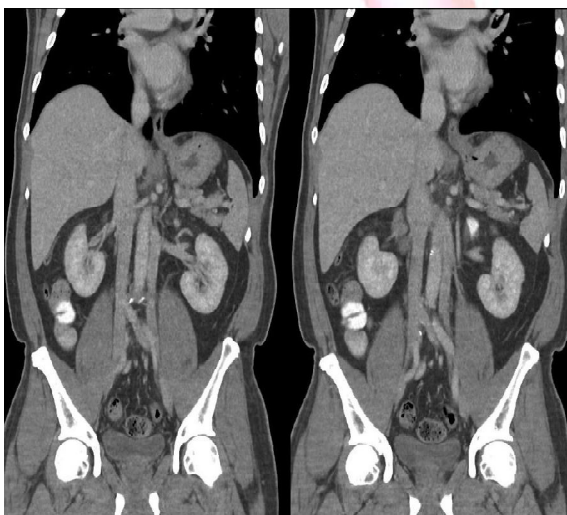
Coronal views of a CT scan showing double inferior vena cava in an asymptomatic patient. The variation is very similar to figure 1, with the duplicated left IVC originating from the left common iliac, terminating at the left renal vein which joins the right IVC by crossing anterior to the abdominal aorta.
